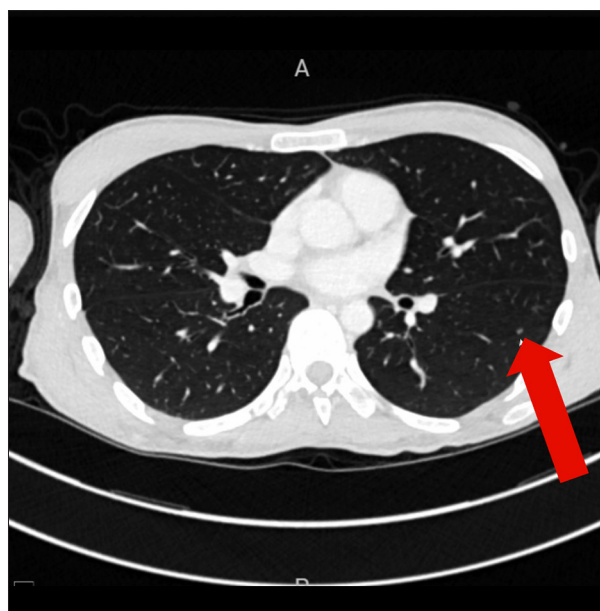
Chest computed tomography showing pulmonary nodule, axial view. One of the only minimal findings on imaging.
